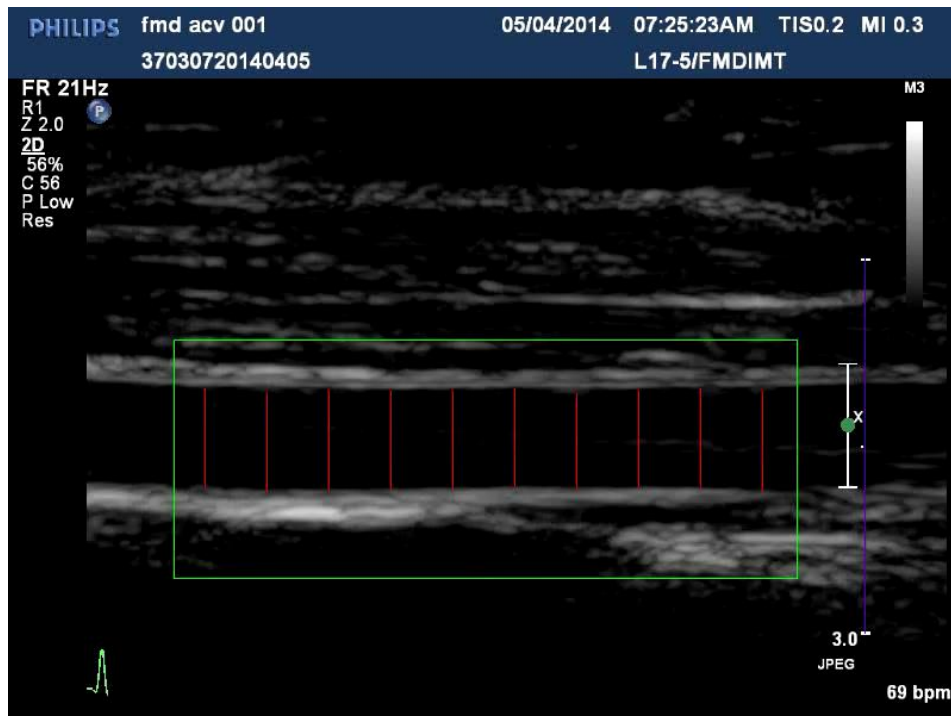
The sonogram of the brachial artery, 10cm proximal from the elbow, green box determines the region of interest, 10 equidistant red lines are used to determine the frame by frame diameter difference over 180sec (15sec pre-cuff release until 165sec).
